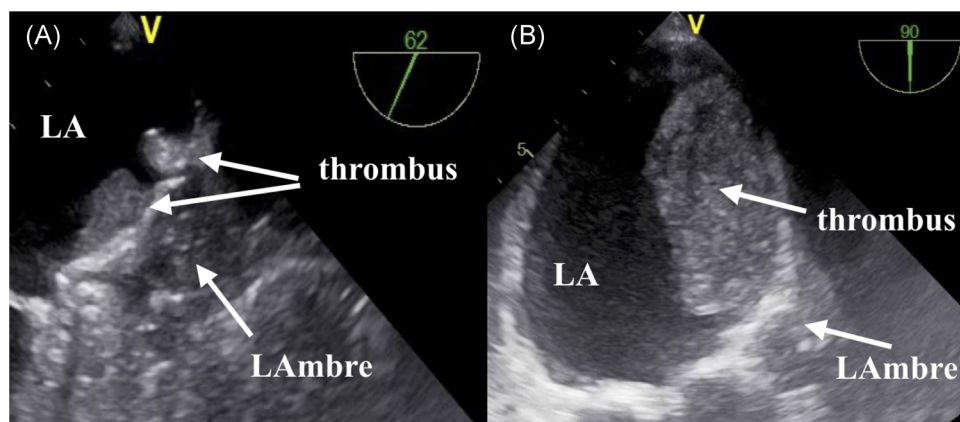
Follow-up images of device-related-thrombi: (A) transesophageal echocardiography after 6-mo revealed a sessile thrombus on a 26/32 mm LAmbré; (B) during 6 months follow-up a large thrombus was detected on a 16/30 mm LAmbré. LA, left atrial
